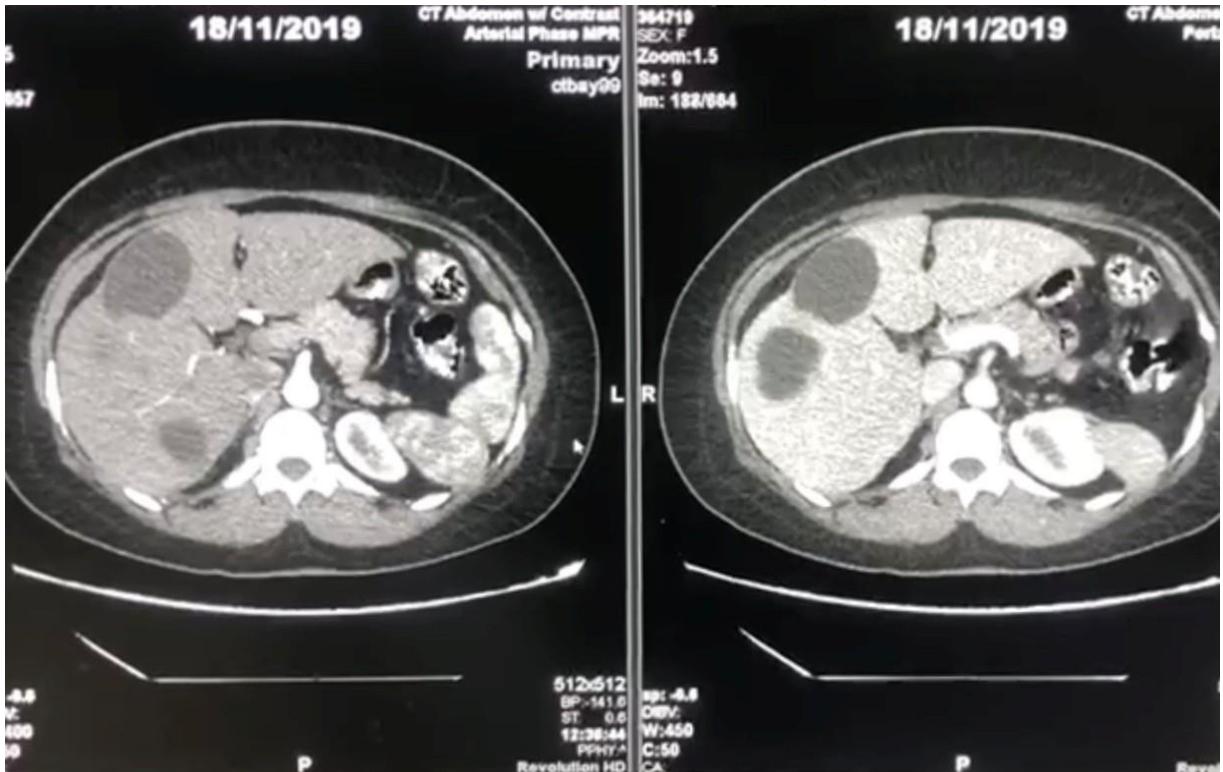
Abdominal CT with contrast shows three hydatid cysts in the right lobe of the liver.
